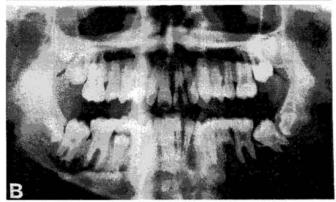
Monozygous twin boys (A and B), aged 14 years, 9 months. Panoramic radiograph A (twin A) lacks a right mandibular second premolar (empty socket under right dm2, seen on the left in the photograph). Panoramic radiograph B (twin B) lacks a left mandibular second premolar (empty socket under left dm2, seen on the right in the photograph).
